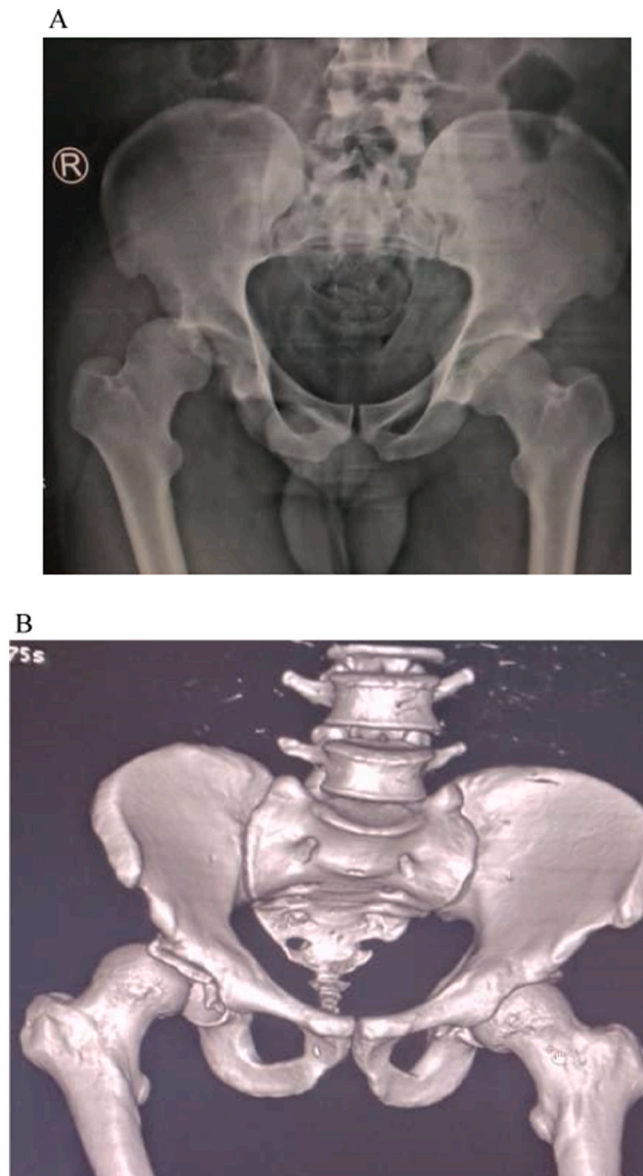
A: Post reduction X-ray showing a reduced concentric left hip, and a nonreduced right hip.
